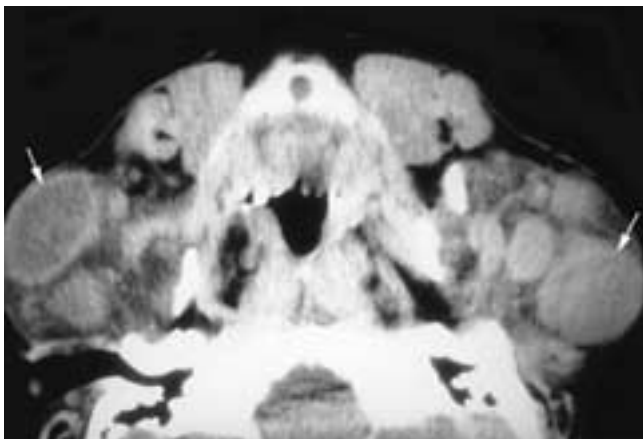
Axial CT scan shows multiple bilateral parotid masses and cervical lymphadenopathy in a patient with sarcoidosis. On either side, there is a solitary cyst (*arrows*) that developed several years after the appearance of the multiple sarcoid granulomas. At biopsy these were found to be lymphoepithelial cysts in a patient with long-standing sarcoidosis.
